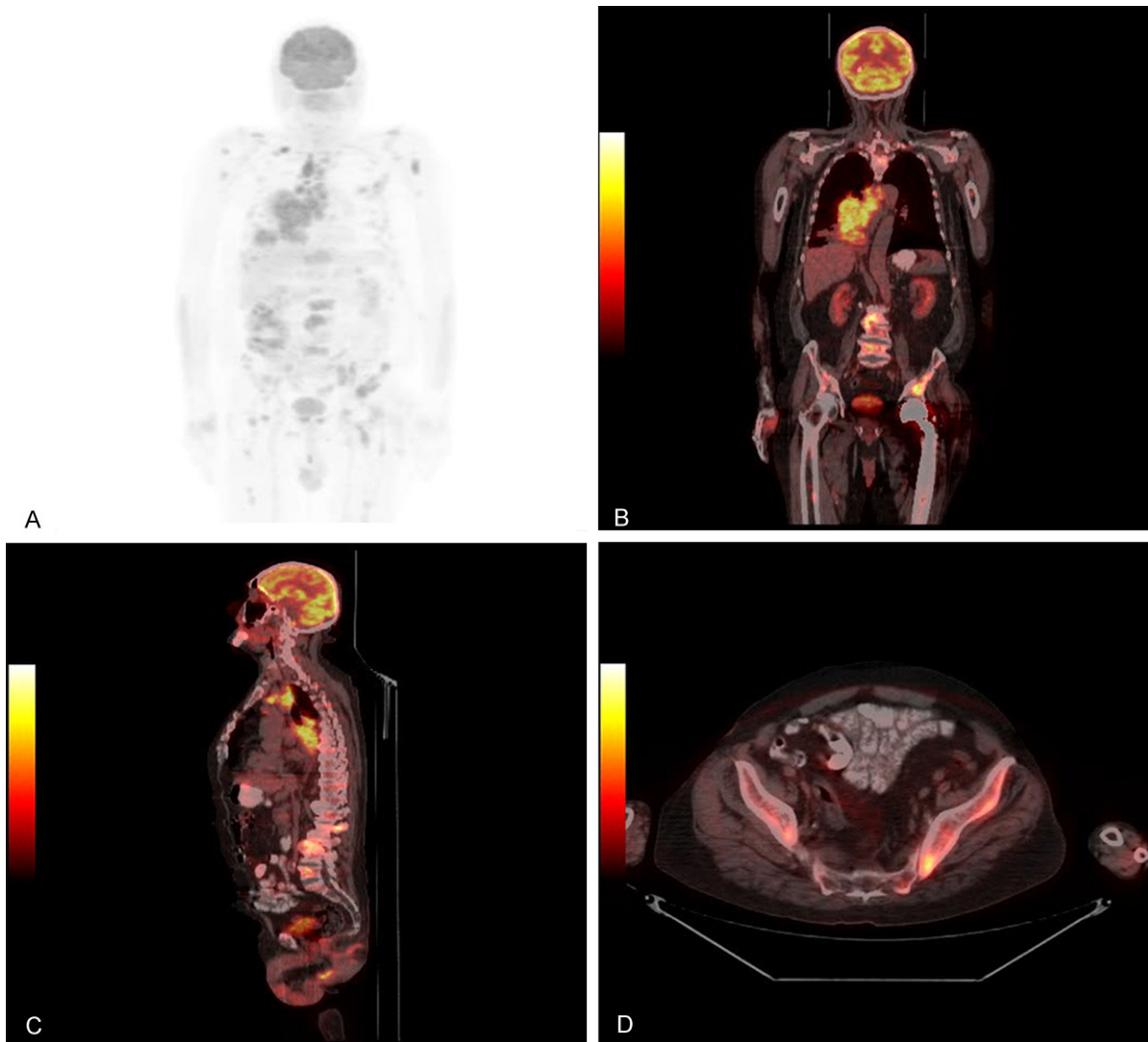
Multiple bone metastasis in a 66 year old male patient diagnosed with small cell lung cancer (patient number 2): A: Positron emission tomography image. B: Coronal PET-CT image. C: Sagittal PET-CT image. D: Axial PET-CT image.
